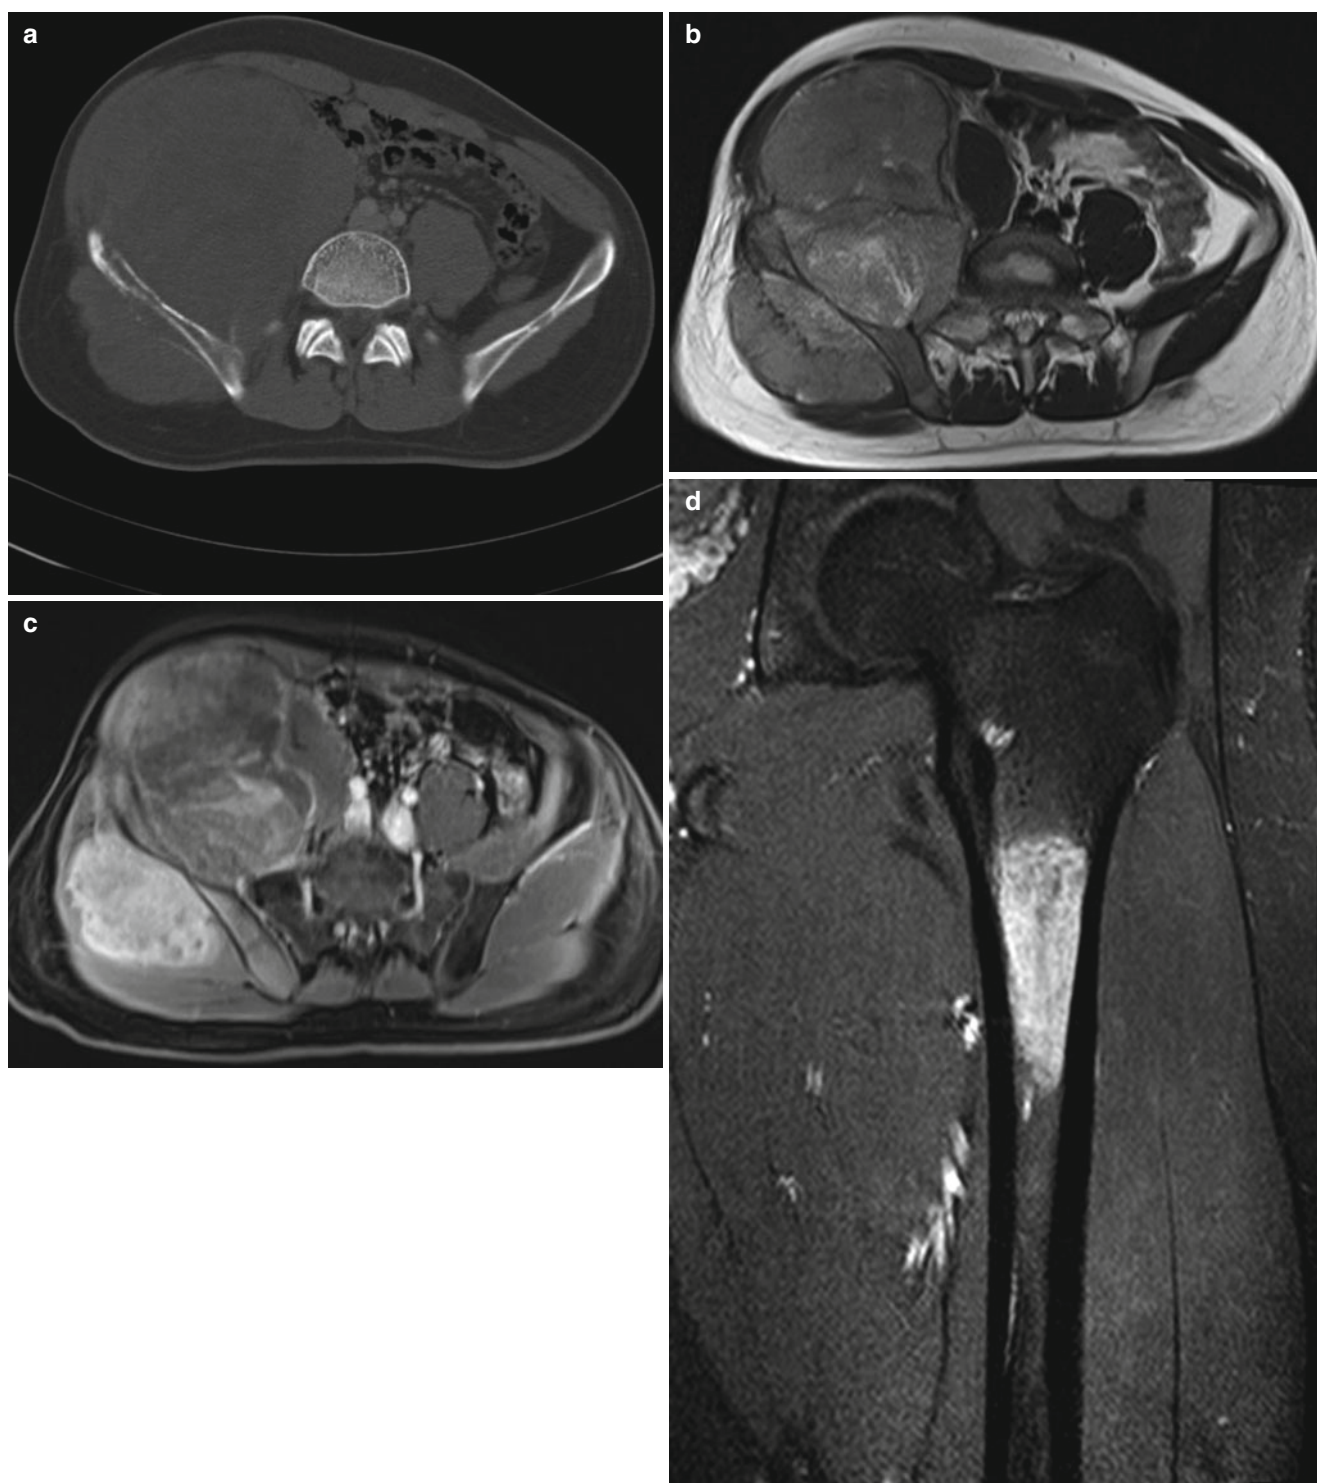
Ewing's sarcoma involving flat bone with bone metastasis. (a) Pelvis CT through the lower abdomen shows a huge soft tissue mass in the right lower quadrant with permeative bone destruction of the right ilium. There is asymmetric bulging of right gluteus muscle as compared to the opposite side with periosteal elevation (*arrowheads*). (b, c) T2-weighted (b) and postcontrast fat-suppressed T1-weighted (c)
